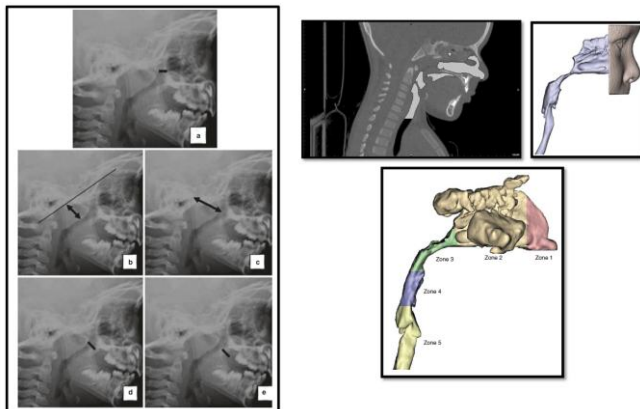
Imaging techniques-lateral cephalogram, computed tomography for assessment of oropharyngeal structures³⁵
